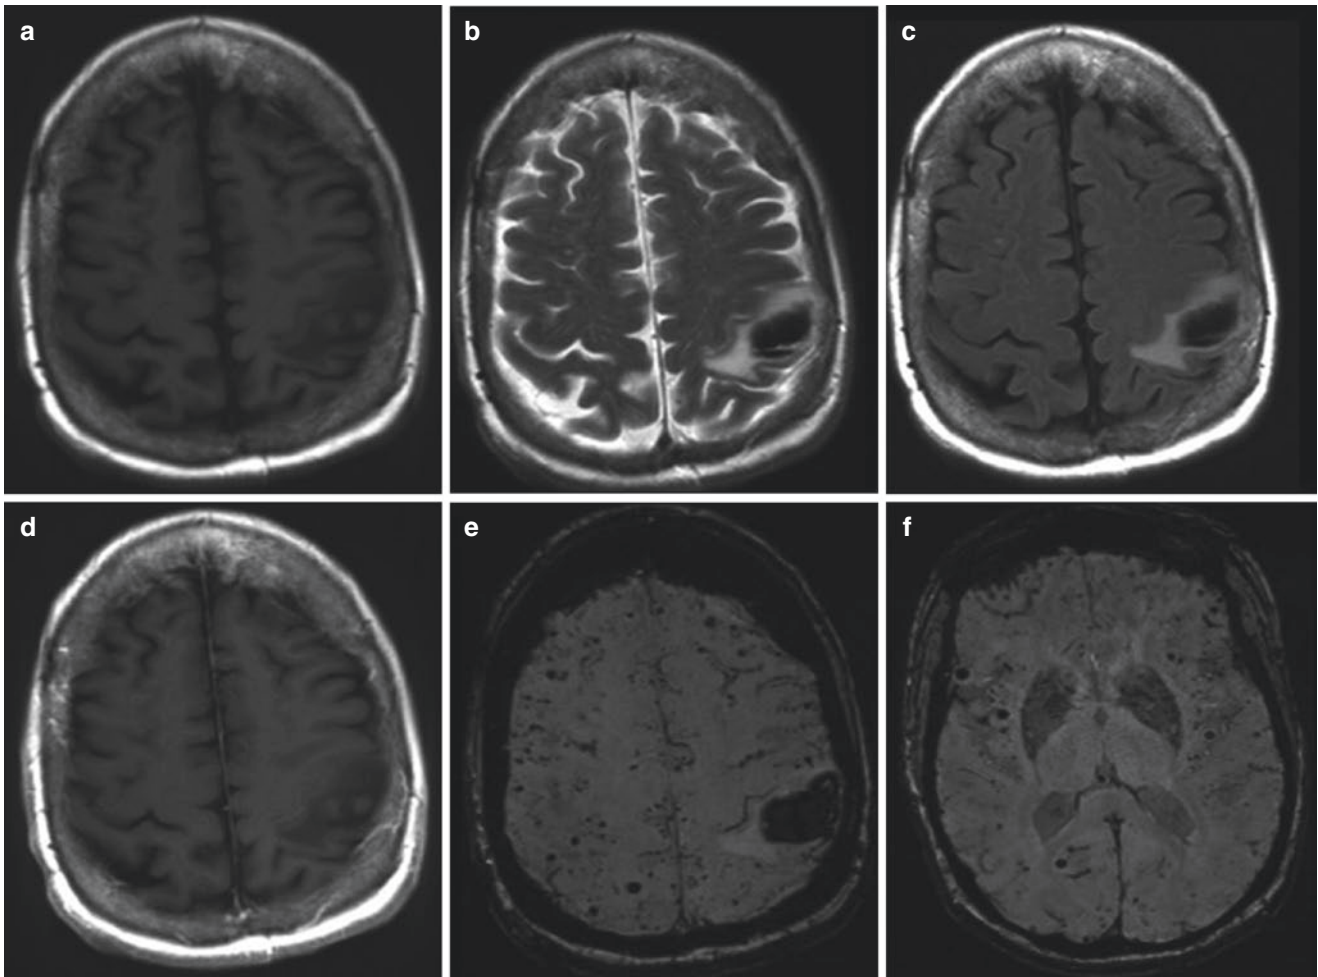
A 70-year-old female with right-sided weakness and amyloid angiopathy. There is an acute parenchymal hematoma in the left parietal lobe that isointense on T1-weighted images (a), hypointense on T2 (b), and FLAIR (c) weighted images, does not show an underlying lesion
